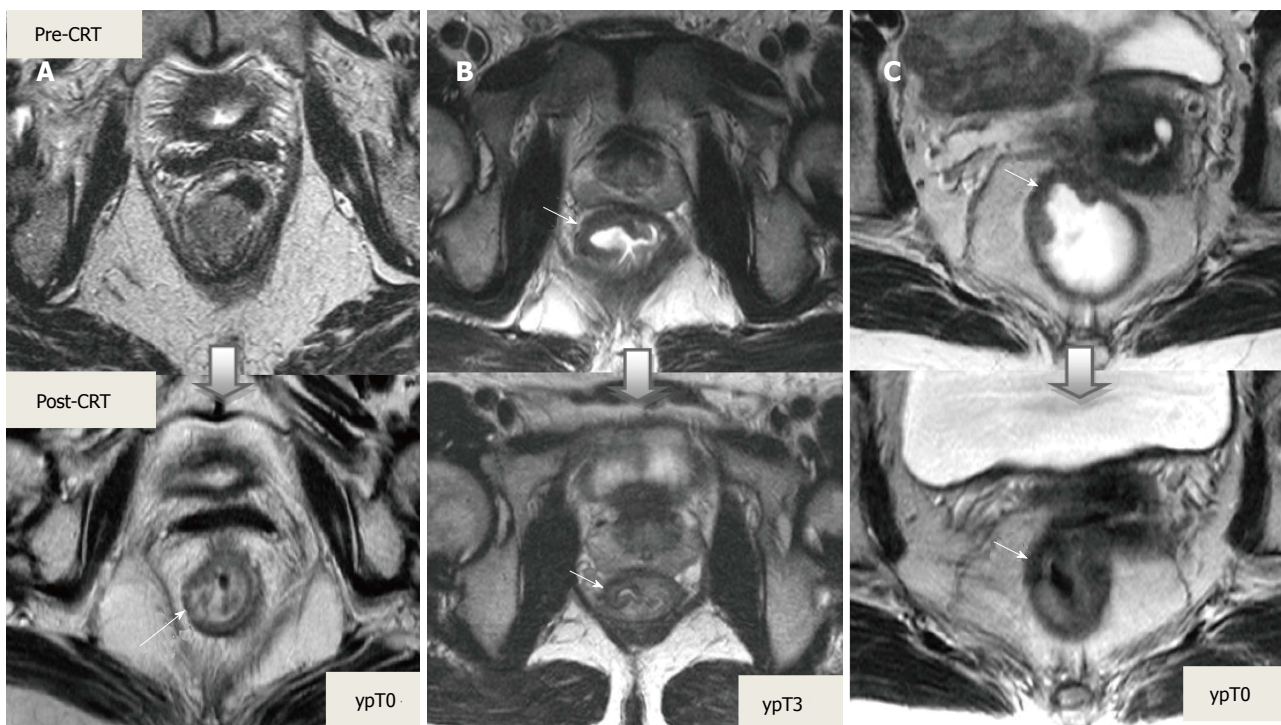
Tumor restaging after neoadjuvant chemoradiotherapy. On T2-weighted MR images in different patients showing baseline and post-CRT images on upper and lower series, respectively. A: In ypT0 rectal tumor, posttreatment axial image shows a normal, two-layered rectal wall (arrow), corresponding to complete response; B: In ypT3 rectal tumor, posttreatment axial image shows normal, two-layered rectal wall (arrow). This is an example for false-negative MR assessment of complete tumor regression; C: In ypT0 rectal tumor, posttreatment axial image shows thick, fibrotic low signal intensity scar (arrow) in pretreatment T3 tumor area. CRT: Chemoradiotherapy.
